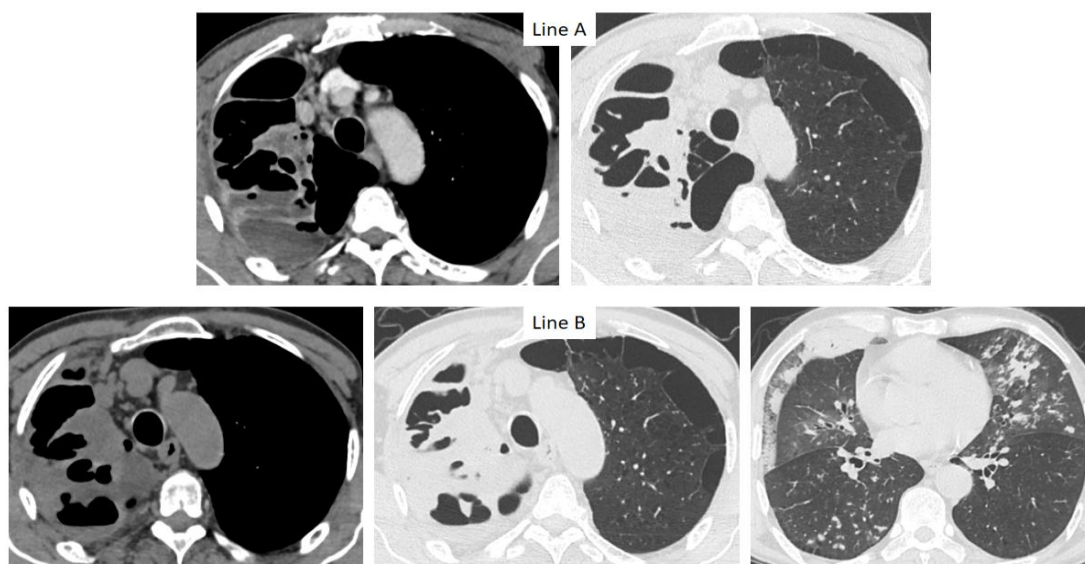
A 59 year-old men presented with fever and increased blood inflammatory markers. First CT (line A) showed complicated bullous emphysema of the right upper lobe. The patients didn't improve under antibiotics. Second CT showed persistence of complicated emphysema and new signs of active TB. Sputum culture positive for TB.
